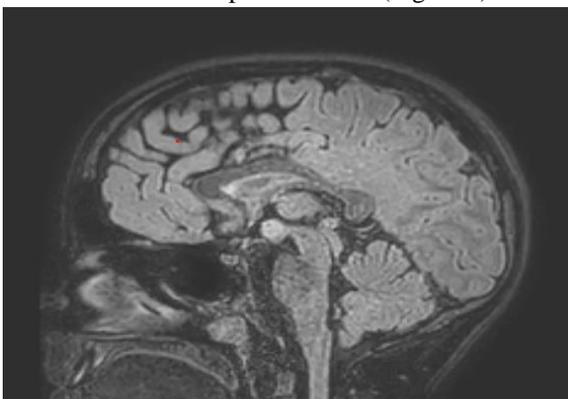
Sessile lesion on the left side of the hypothalamus with a hyperintense signal on T2/FLAIR and a hypointense signal on T1 compared to the periventricular white matter, without significant enhancement after contrast agent injection.
